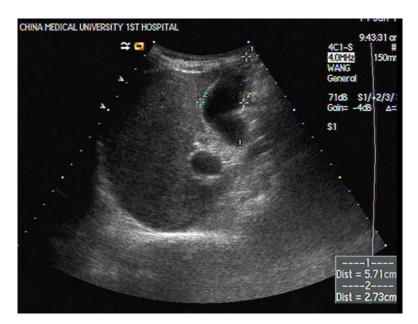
The ultrasonography showed a lower echo nodule measuring 5.71×2.71 cm in the liver. The nodule was relatively well circumscribed.
